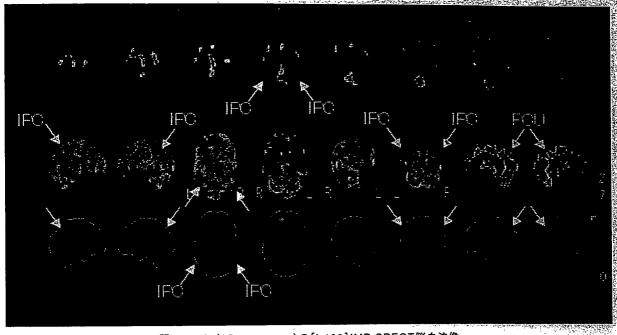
MCI(AD converter)の[I-123]IMP SPECT脳血流像 上段から下段へ, 断層像, 3D-SSP投影像, 3D-SSP Zスコア画像. MCI時点で, 下部頭頂葉(IPC), 楔前部(PCU)に血流低下が認められ, アルツハイマー病の病態が存在することが疑われる.
